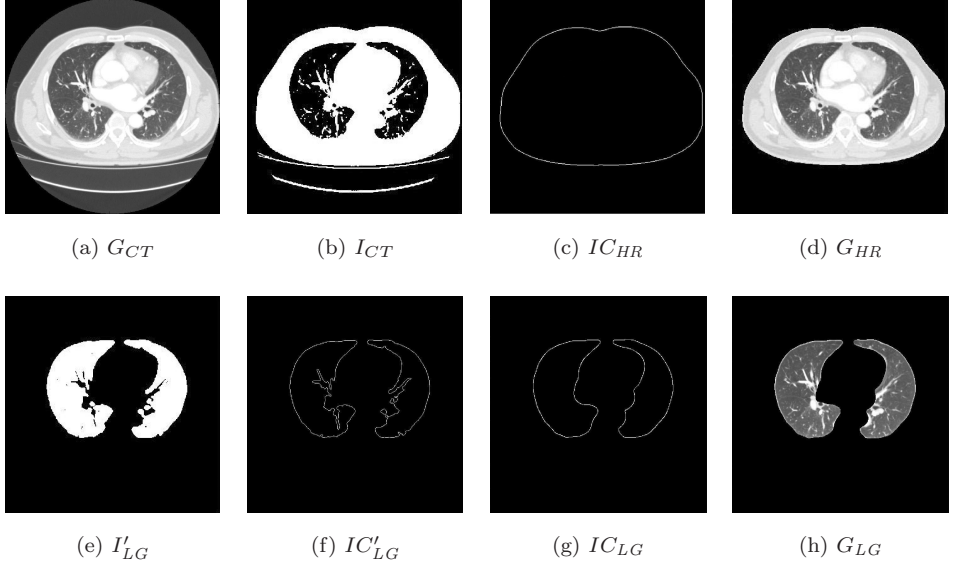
Automatic lung segmentation sequence. (a) Original CT image  $G_{CT}$ . (b) Transform  $G_{CT}$  into a binary image  $I_{CT}$  by thresholding. (c) Get the inner border  $I_{CHR}$  with boundary tracking algorithm. (d) Compute the thoracic image  $G_{HR}$  by region growing method. (e) Acquire the binary lung image  $I'_{LG}$  by thresholding to  $G_{HR}$ . (f) Produce the inner border  $I'_{LG}$  of  $I'_{LG}$  with boundary tracking algorithm. (g) Change  $I'_{LG}$  into the final inner border  $I_{CLG}$  with CBC. (h) Obtain the final lung parenchyma  $G_{LG}$  with region growing method.
